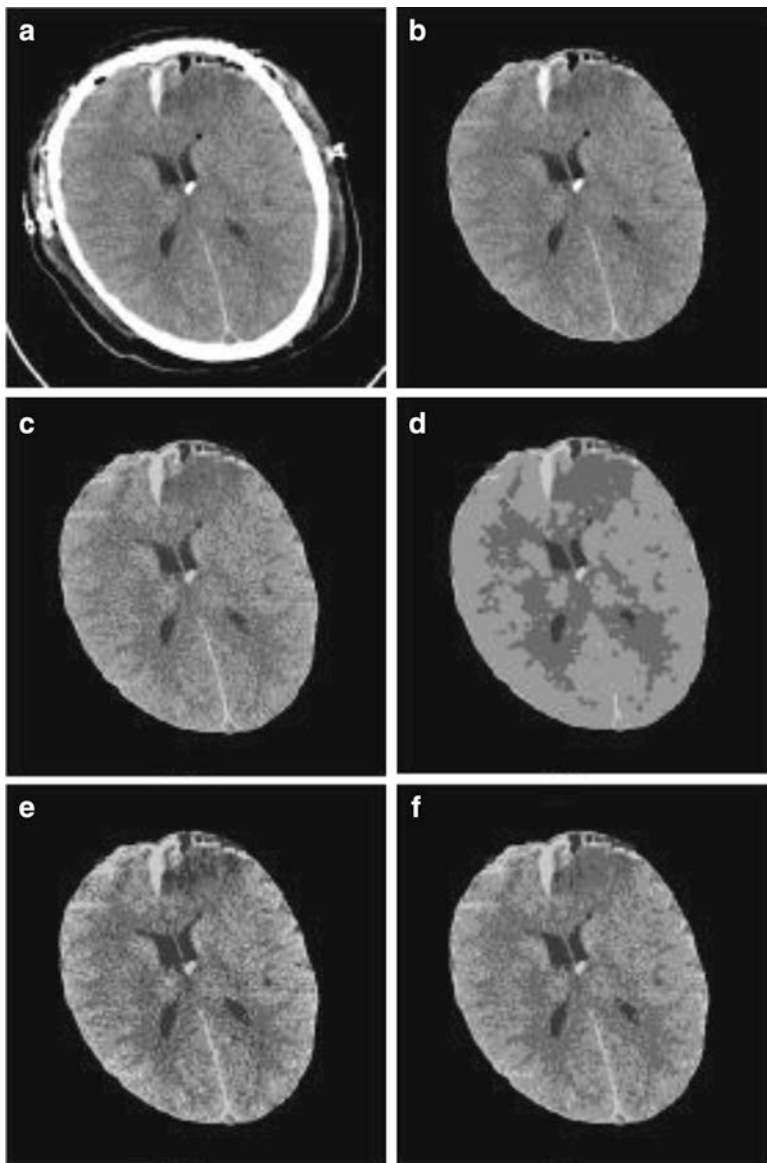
Comparing segmentation methods. (a) Actual CT image. (b) CT image without the skull. (c) Result of K-means algorithm. Four clusters are identified with initial seeds. Noise and uneven intensity distribution have created some holes in the segmentation. (d) ICM segmentation with K-means as initial result. ICM gives smoother segmentation, although some small parts are missing. (e) MASP segmentation. MASP has resulted in more noise compared to ICM (*the right upper corner* is labeled wrongly as part of ventricles). (f) Modified MASP segmentation which is not as smooth as ICM, but resulted in less noise than MASP [6]
